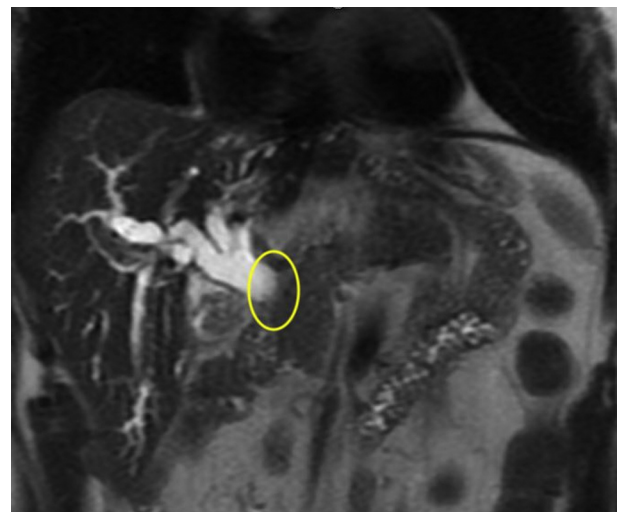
Magnetic resonance imaging shows severe intrahepatic biliary dilation with abrupt cut off at the common hepatic duct region (*yellow oval*).
